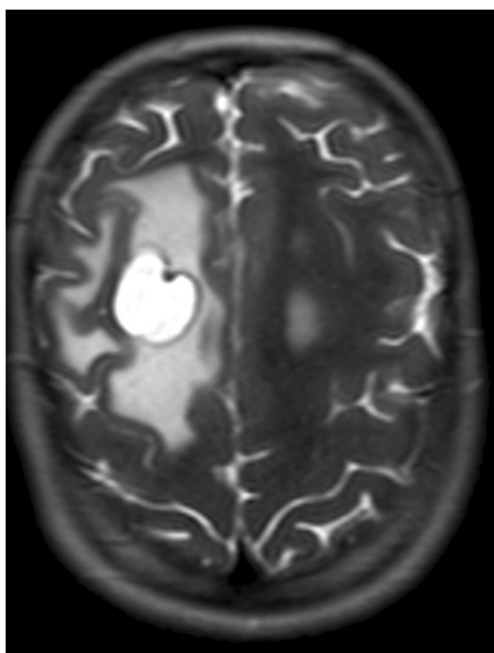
Porencephalic cyst. Axial T2-weighted magnetic resonance imaging (MRI) of the brain showing a 2.6-cm right frontal PC. The right frontal Ommaya catheter can be seen associated with it. There is a large amount of edema in the white matter surrounding the PC
